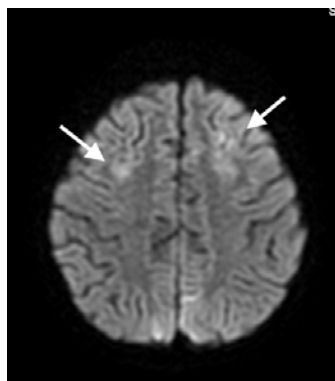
There is restriction of the bilateral frontal gyral pattern (arrows) on diffusion-weighted MR imaging.
